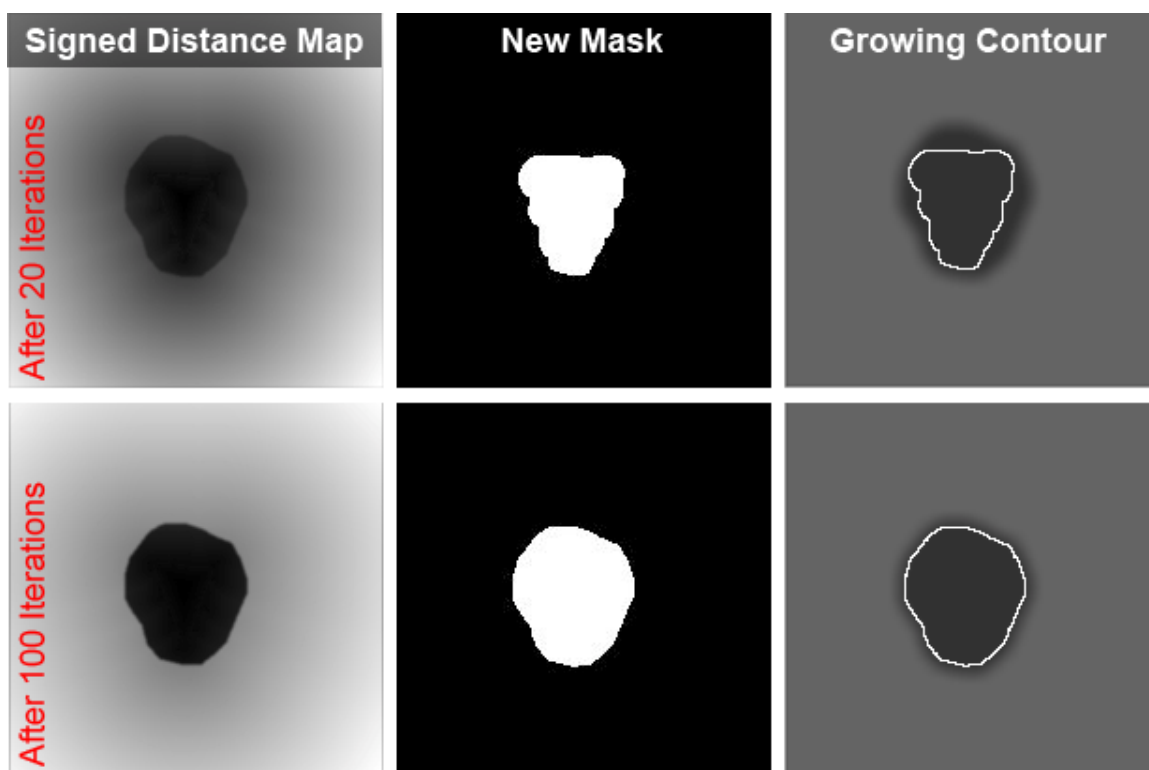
Signed distance map and the corresponding new mask and contour after 20 (top row) and 100 (bottom row) iterations. The growing contour is shown overlaid on the surrogate MR image from which the contour is being grown.
